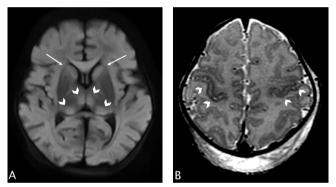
Axial diffusion-weighted magnetic resonance image shows hyperintensity in the anteromedial and ventrolateral thalami (arrowheads in A), and also in the basal ganglia (arrows in A). Axial T2WI shows hypointensity in the sensorimotor cortices bilaterally (arrowheads in B). These findings are highly suggestive of severe hypoxic-ischemic insult.
